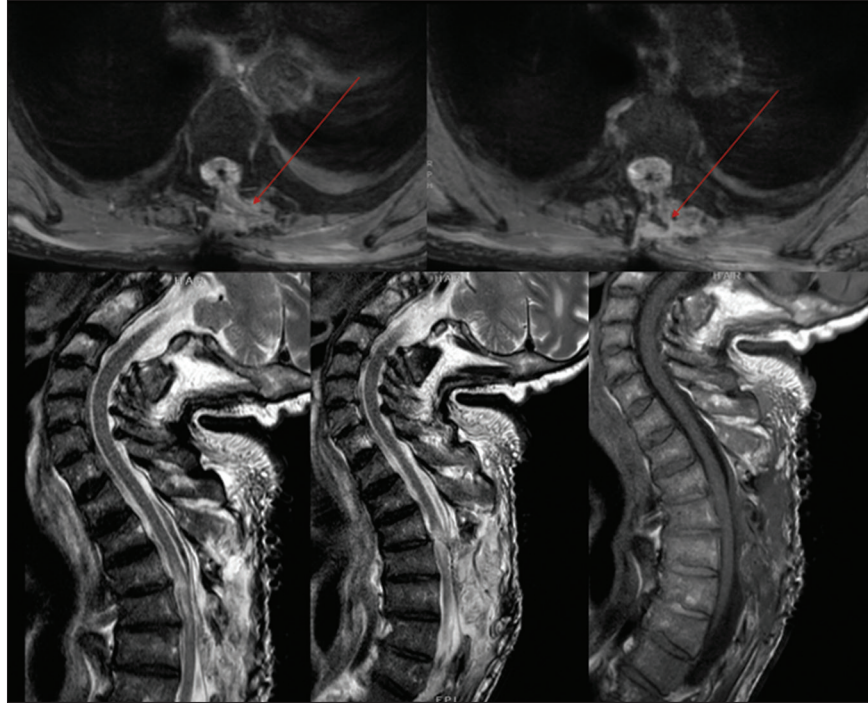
Postoperative magnetic resonance imaging of patient 1 (axial and sagittal views). Red arrows indicate the multifidus muscle flap rotated over the dura mater.
